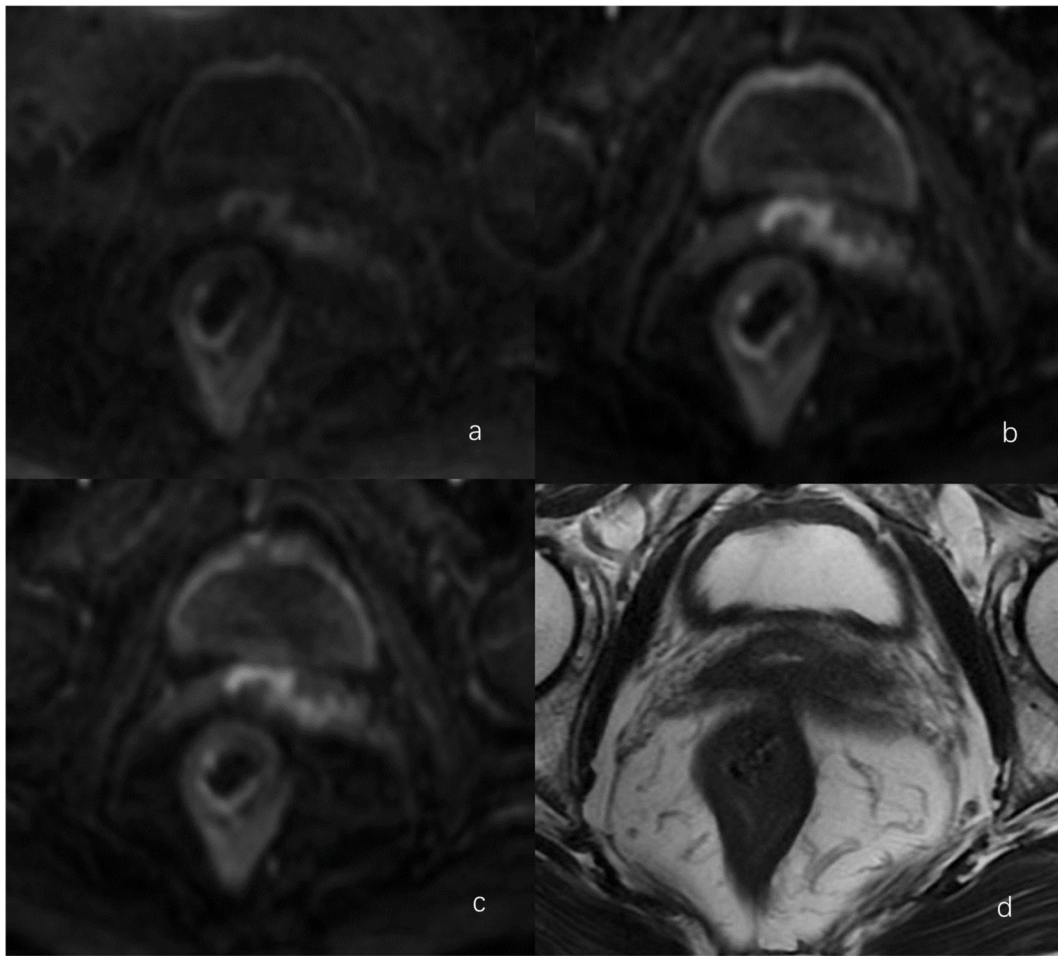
MRI images of cervical cancer involving the vagina. a) ssEPI DWI, b) MUSE DWI, c) RPG-MUSE DWI, d) T2WI. Vaginal cancer foci were poorly visualized on T2WI, and the margins were more clearly shown on RPG-MUSE DWI image.
